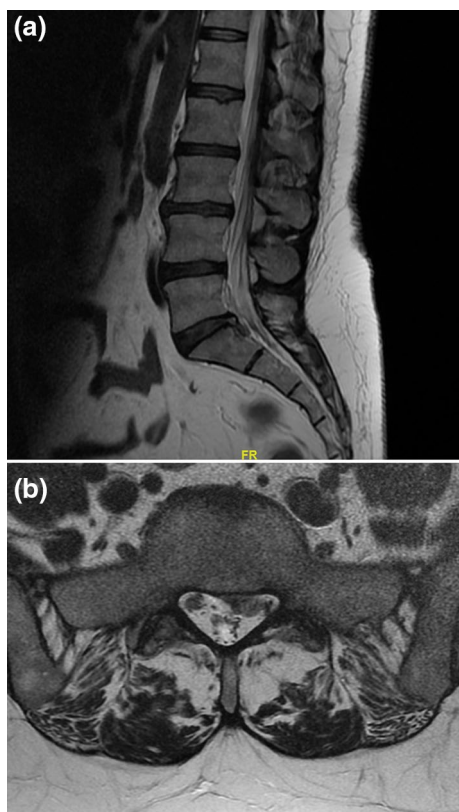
52-year-old female patient with a left L5–S1 disc herniation with an intact posterior longitudinal ligament. a T2-weighted sagittal view; b T2-weighted axial view
